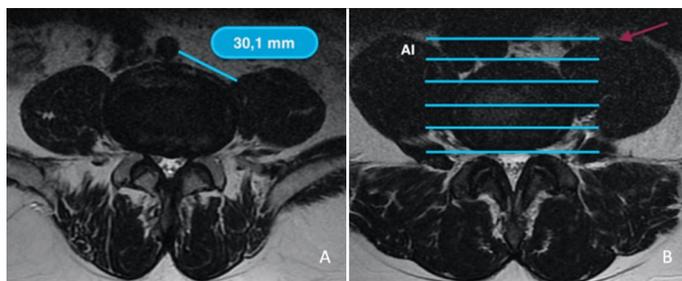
A, 47-year-old woman, T2 MRI at L4/L5 disc level, with grade 3 oblique corridor. B, 59-year-old man, T2 MRI at L4/L5 disc level, with modified Moro classification AI. Both patients have an oblique corridor accessible for the oblique lumbar approach.
